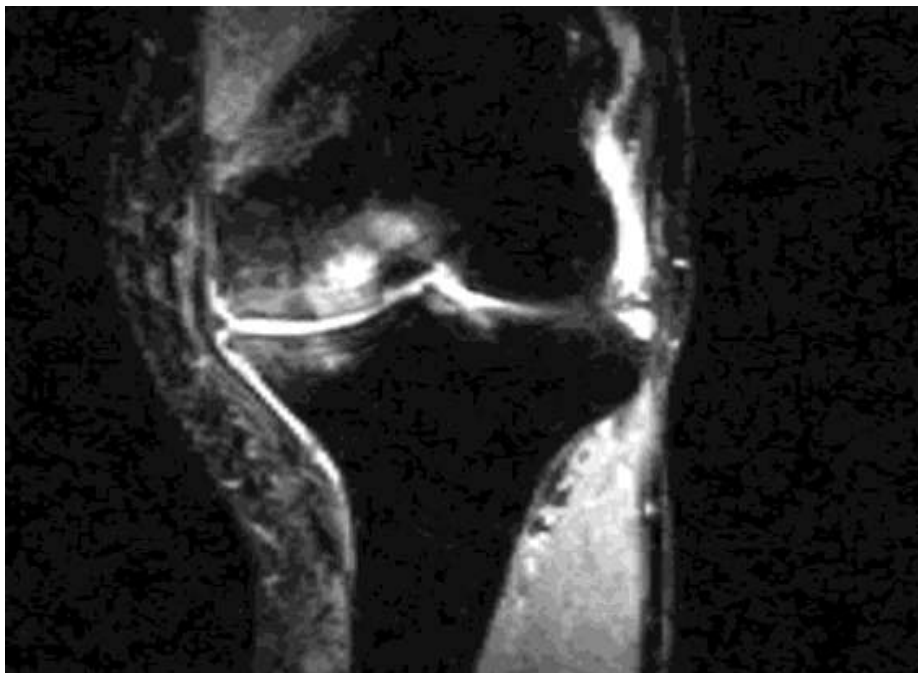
Coronal MRI image (STIR sequence) of Right Knee in Rheumatoid Arthritis patient showing bone marrow edema in distal femur.
